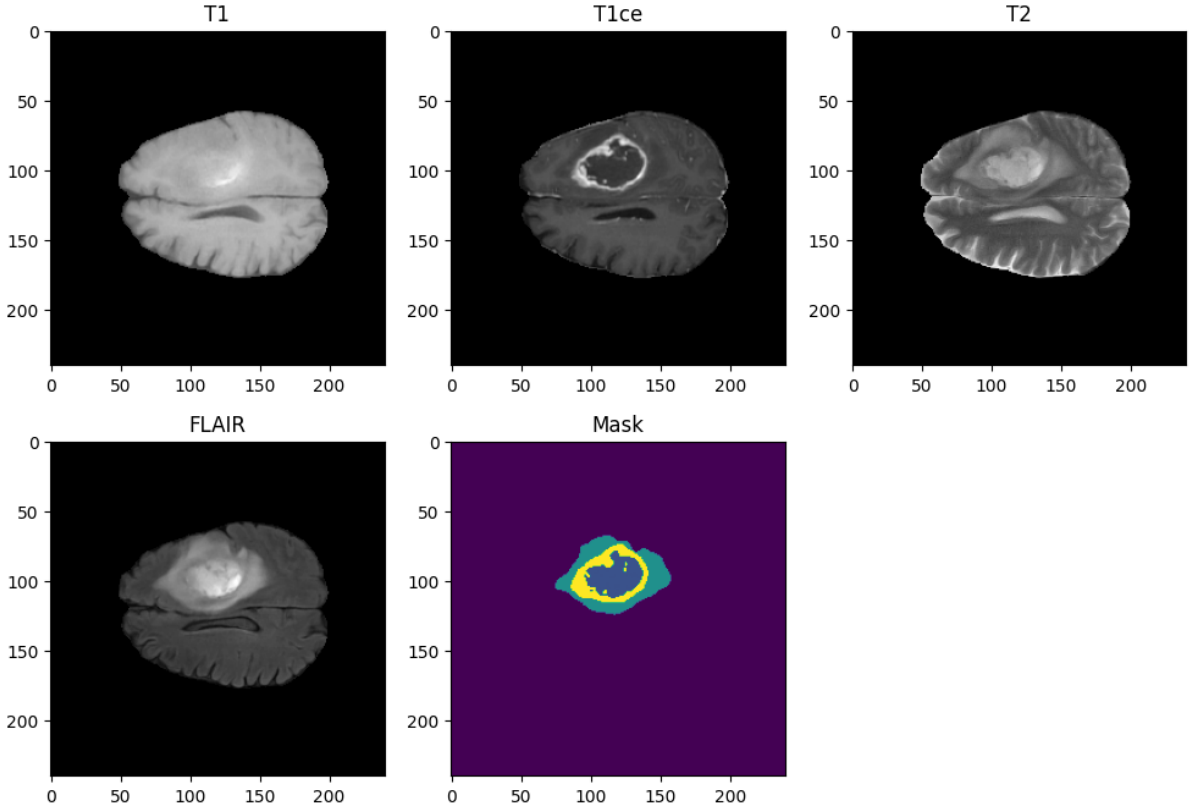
Different modalities of an MRI image and the mask
